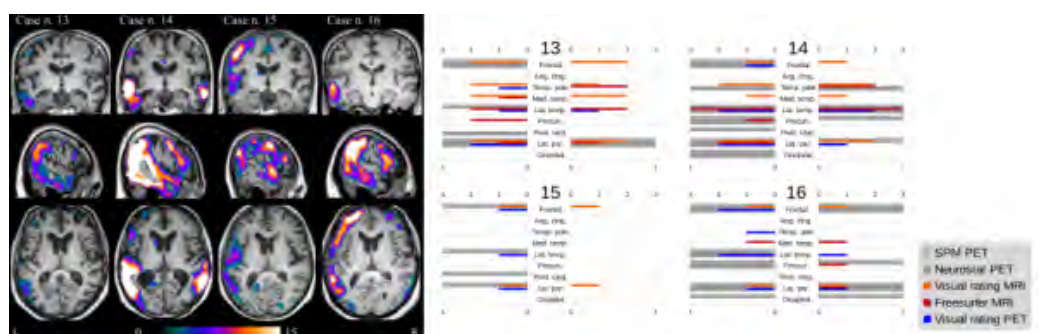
Combined T1-MRI, PET uptake and SPM maps (left) and atrophy and hypometabolism ratings (right) in progressive non-fluent aphasia. Left perisylvian atrophy of variable severity is accompanied by lateral frontal and lateral temporo-parietal hypometabolism, which were particularly marked in cases 14-16. For images and plots, left side corresponds to left hemisphere.
